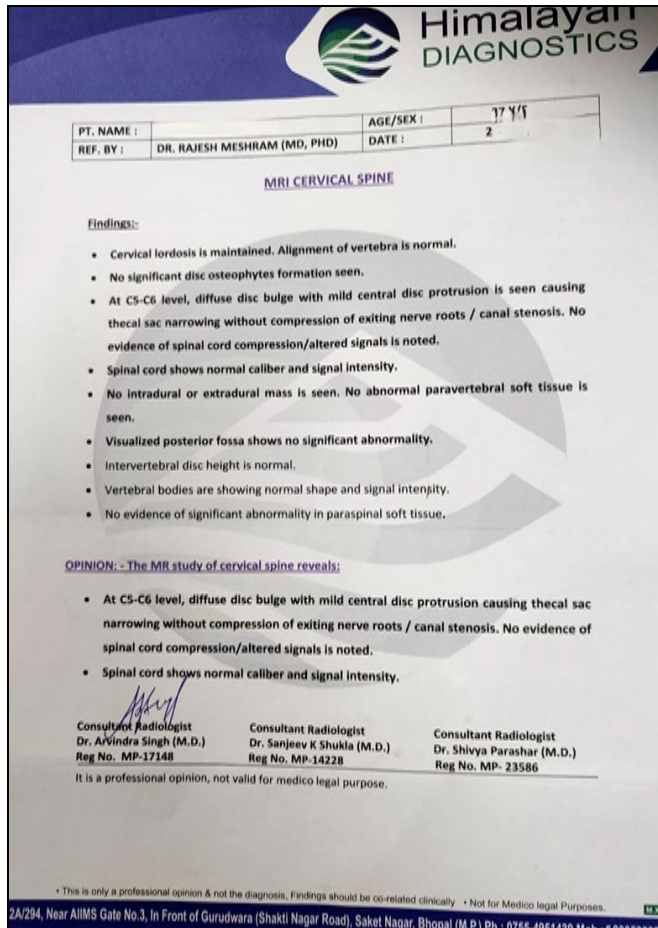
Patient MRI Report
